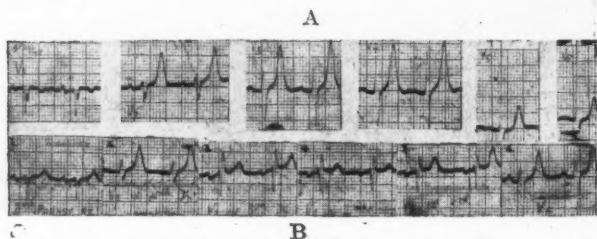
(A) Wilson leads (V_1 to V_6) and (B) special registration in the vertical line of V_2 and V_3 in the second and third intercostal space. (1: 2nd right parasternal; 2 and 3: V_2 in 2nd and 3rd; 4 and 5: V_3 in 2nd and 3rd I.C.; 6: V_E .)
